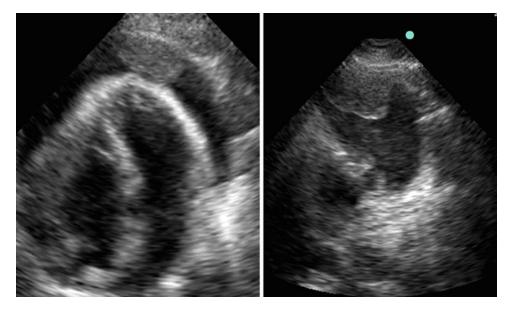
Two-dimensional echocardiography. Pericardial metastasis secondary to a colon carcinoma. The off-axis projection in the *right panel* clearly shows that the mass is
